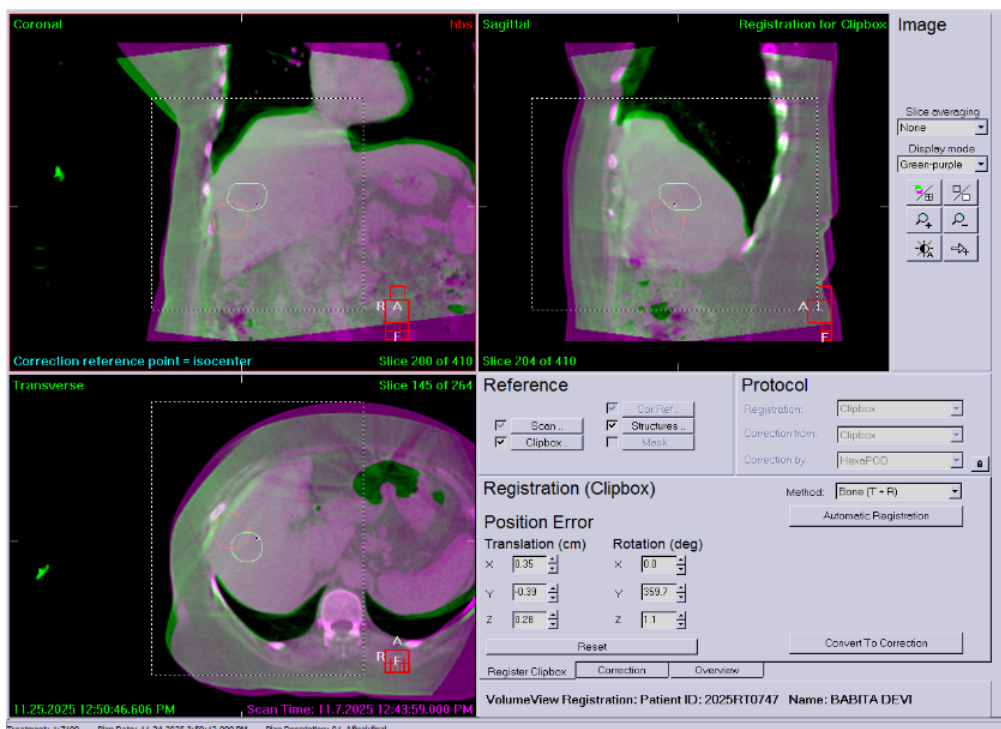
CBCT-Based Patient Positioning Followed by Six-Degree-of-Freedom Hexapod Couch Adjustment in the Same Treatment Session
